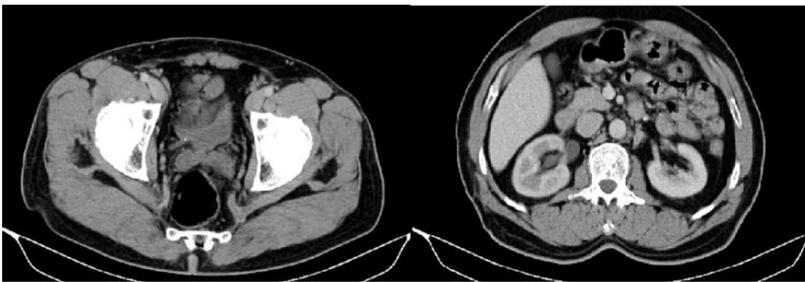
Renal Pelvis Rupture in CT
